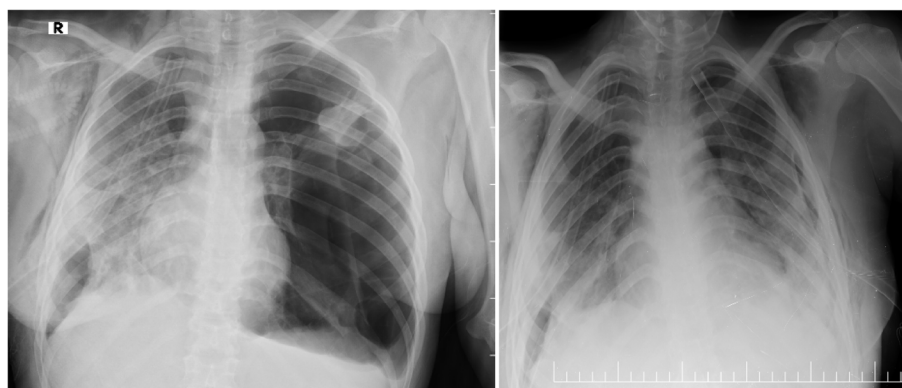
A Portable chest radiograph demonstrating a left-sided tension pneumothorax, with chest tube and consolidation on the right lung. There is chest tube and lung contusion on the right side. B Chest X-ray after chest tube insertion. There are complete resolution of the pneumothorax, and both lungs are fully expanded
